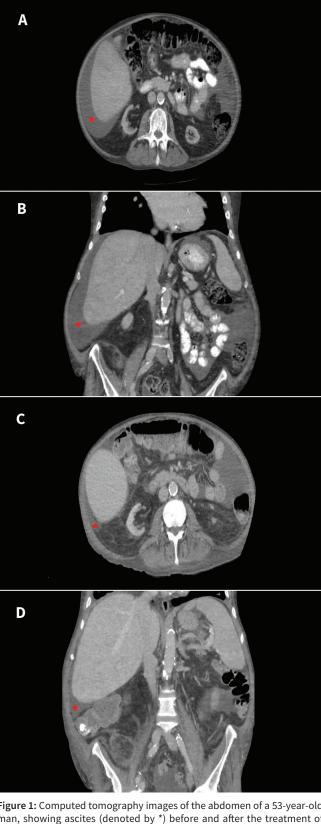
Computed tomography images of the abdomen of a 53-year-old man, showing ascites (denoted by *) before and after the treatment of pulmonary *Mycobacterium avium* complex infection. (A) and (B): Axial and coronal images show substantial ascites before the diagnosis and treatment of the pulmonary mycobacterial infection. (C) and (D): Four weeks after treatment with ethambutol, moxifloxacin and azithromycin, a substantial reduction in the ascites occurred.
